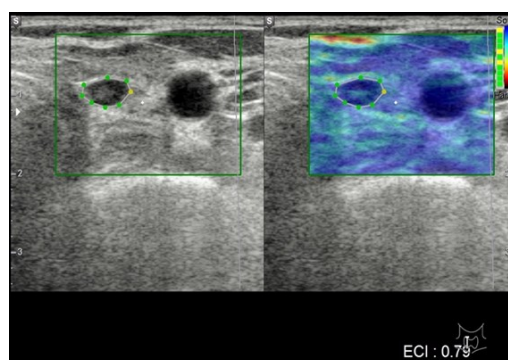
Example of ultrasound elastography image showing a thyroid nodule circled within region of interest and its Elastography Contrast Index of 0.79.
